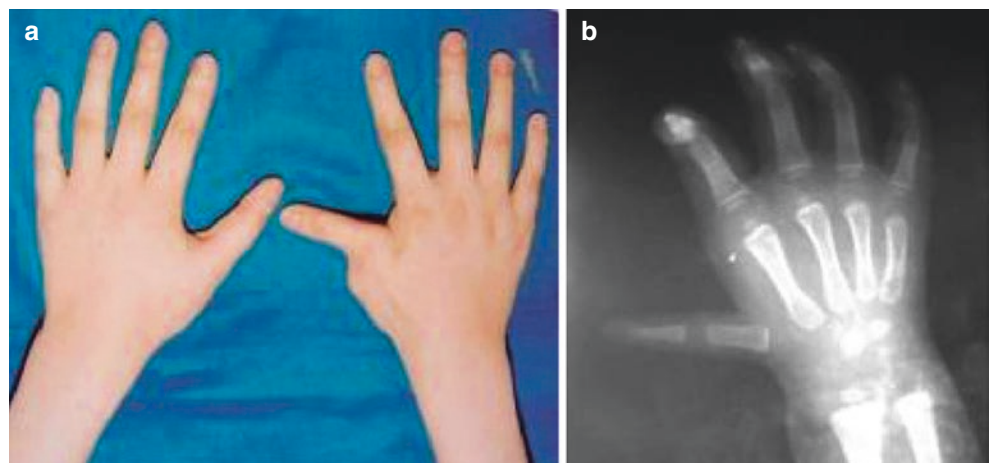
Case five: type IIIc thumb dysplasia of the right hand. (a) Hand appearance. (b) X-ray findings
